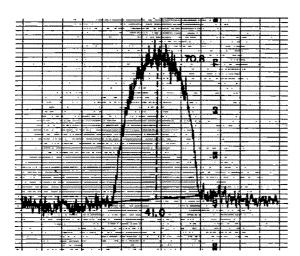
The densitometric tracing of one of the tubes of the *iodine standard*. The *attenuation factor* is calculated from the light transmittance at the top of the curve (70.8 per cent), and from the light transmittance in the middle of the base line (41 per cent). The corresponding optical density is the logarithm of these values. The two relative roentgen exposures necessary to produce these two densities are calculated from the sensitometric curve. The ratio of these two exposures is the attenuation factor.
